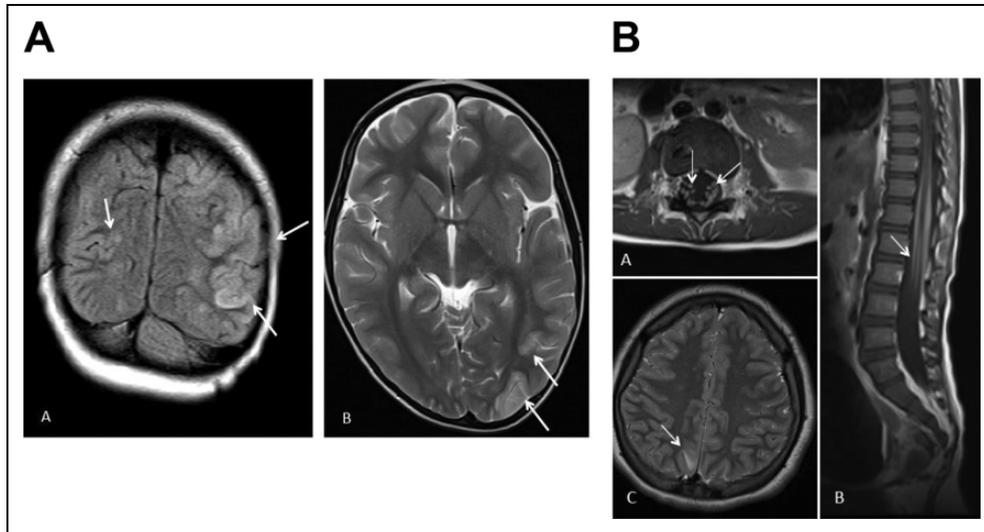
A, Patient 1: Magnetic resonance imaging (MRI) coronal FLAIR (A) at the level of the occipital lobes and axial T2-weighted images (B) shows multiple patchy areas of cortico–subcortical hyperintense signal (white arrows) in both posterior temporal and occipital lobes (more on the left). Radiological findings are consistent with posterior reversible encephalopathy syndrome (PRES). B, Magnetic resonance imaging (MRI) axial (A) and sagittal (B) postcontrast T1-weighted images in patient 1 shows diffuse enhancement and thickening of the cauda equina roots (white arrows in A and B); findings in keeping with Guillain-Barré syndrome (GBS). Axial T2-weighted images in patient 2 (C) show small right parietal subcortical area of hyperintense signal (arrow) in keeping with posterior reversible encephalopathy syndrome (PRES).
